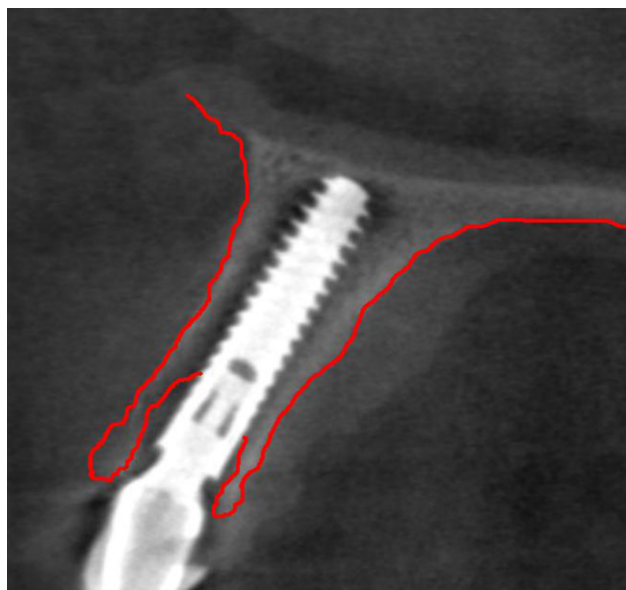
Cone beam computed tomography slide done after placement of the immediate temporary restoration.
